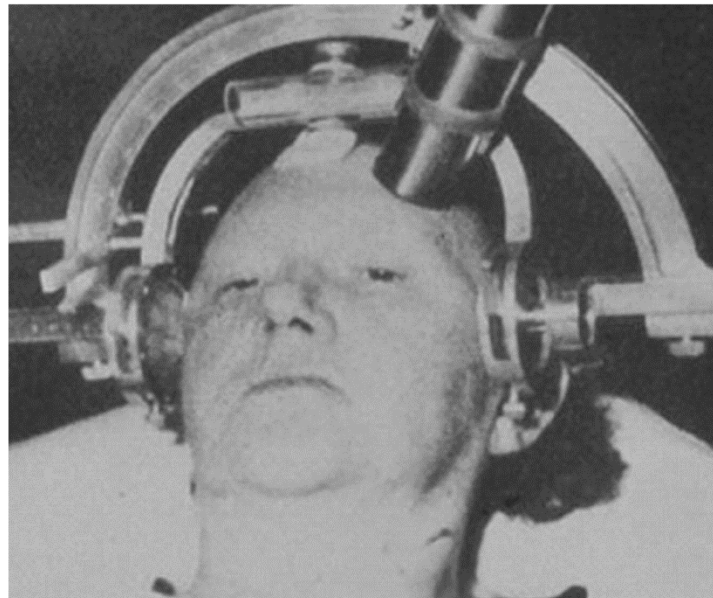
First Radiosurgery treatment using a 200 kVp x-ray tube mounted on a stereotactic frame<sup>1</sup>.
